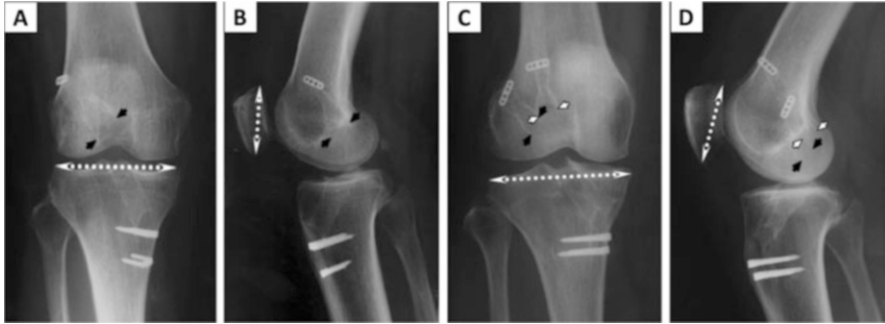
The radiographic measurement method of bone tunnel width. Bone tunnel enlargements were observed in two-dimensional plane. (a) Anterior/posterior view on single-bundle ACL reconstruction. (b) Lateral view on single-bundle ACL reconstruction. (c) Anterior/posterior view on double-bundle ACL reconstruction. (d) Lateral view on double-bundle ACL reconstruction (Figure from “Kawaguchi Y, Kondo E, Kitamura N, Kai S, Inoue M, Yasuda K (2011) Comparisons of femoral tunnel enlargement in 169 patients between single-bundle and anatomic double-bundle anterior cruciate ligament reconstructions with hamstring tendon grafts. *Knee Surg Sports Traumatol Arthrosc* 19 (8):1249–1257”)
